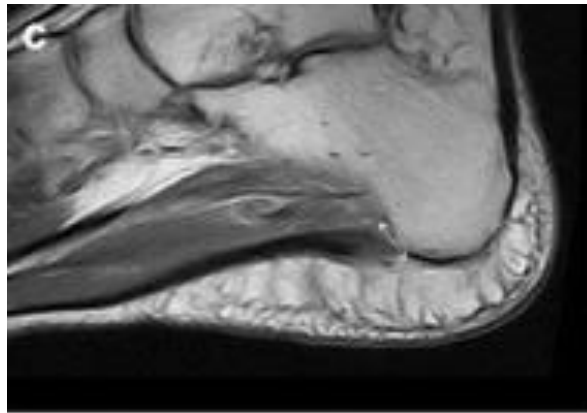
MRI - T1 weighted image (c), the double-headed arrow indicates thickening of the plantar fascia at the calcaneal origin, as well as the intrasubstance region of transitional and high signal intensity (Draghi et al., 2016)
